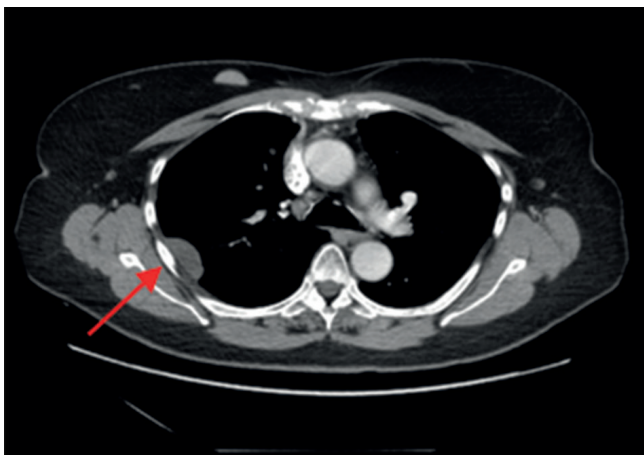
Computed tomography (CT) scan after 12 cycles of treatment with trabectedin, showing disease progression according to RECIST criteria.
